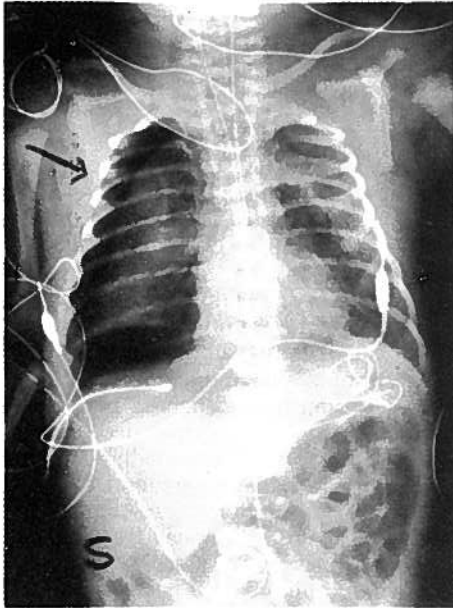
Chest roentgenogram of newborn with stippling of the lung characteristic of respiratory disease syndrome (R.D.S.). The newborn also developed pneumothorax requiring chest tube drainage to relieve hypoxia.
